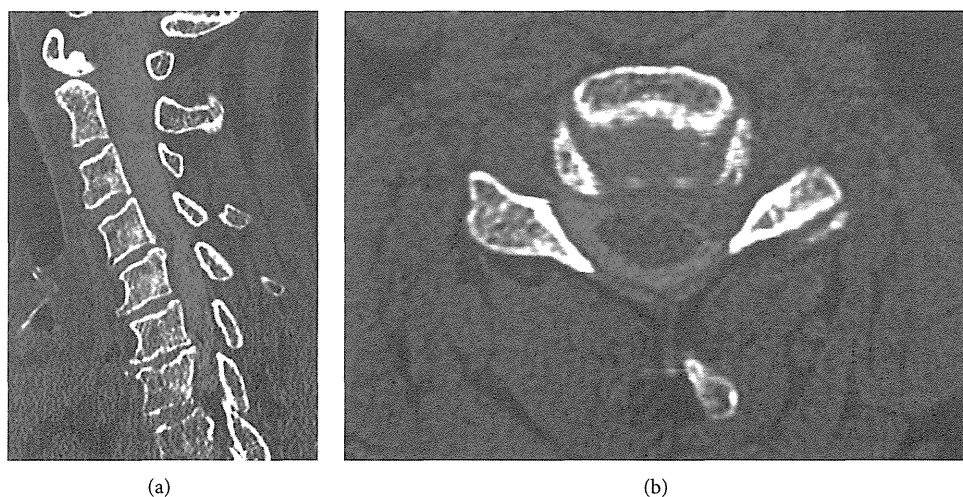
Computed tomography after myelography showing left-side C4-5 disc herniation. (a) Parasagittal view and (b) axial view at the C4-5 level.
